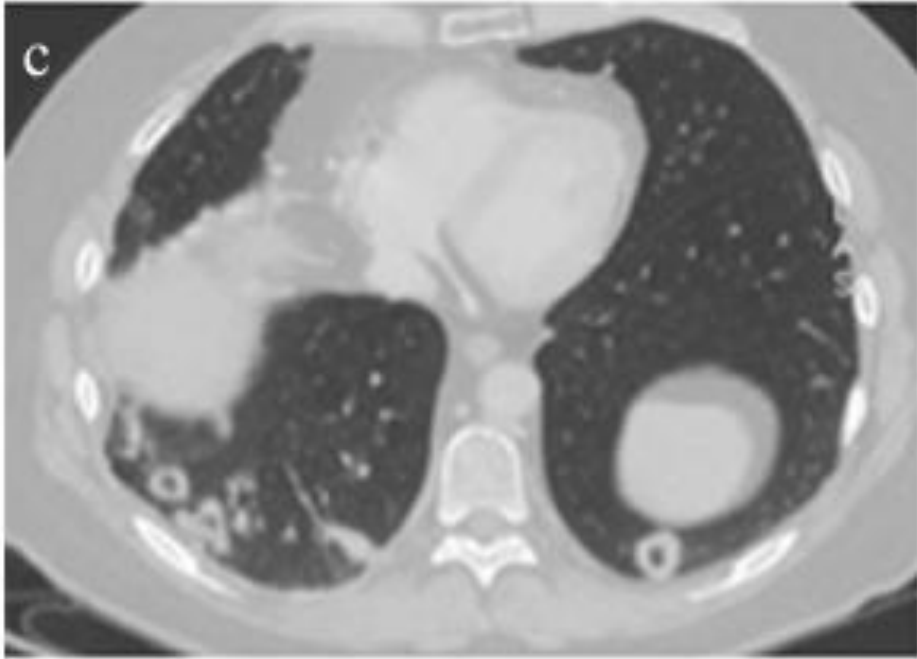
▲ Ausgedehnte Pneumonitis in der Röntgenübersichtsaufnahme (a) sowie in der Transversalebene eines nativen CT des Thorax (b). Nach Therapie mit systemischen Steroiden kam es zu einer vollständigen Rückbildung (c). Die Patientin erhielt zuvor Nivolumab im Rahmen einer Studie zur Erstlinienbehandlung eines klassischen Hodgkin-Lymphoms
